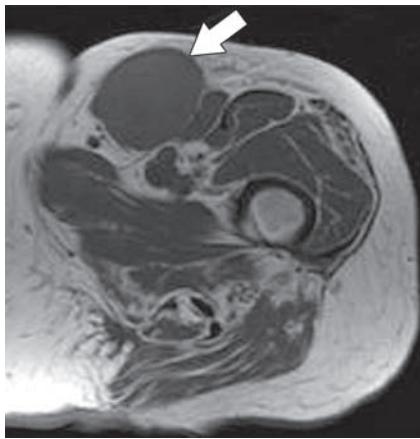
Sarcoma requiring adjuvant radiation therapy. Axial T1-weighted MR image shows a malignant fibrous histiocytoma in the left inguinal region (arrow). The femoral triangle does not have good fascial boundaries; therefore, this tumor requires adjuvant radiation therapy to ensure an adequate local margin and reduce the risk of local recurrence.
